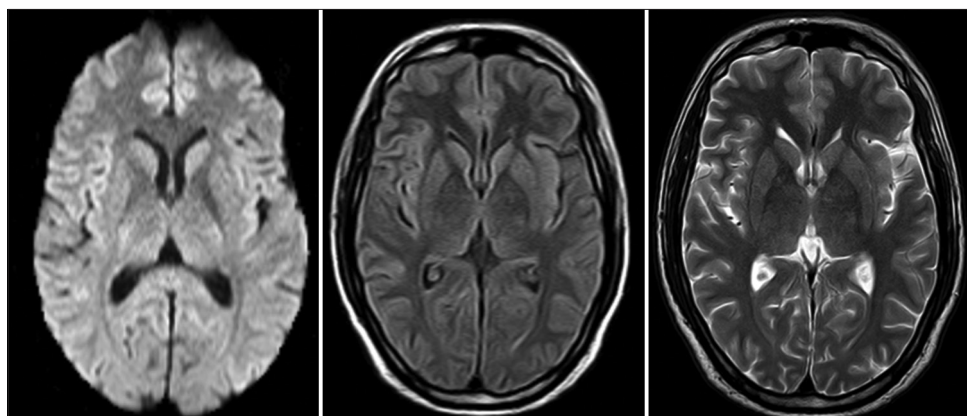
Magnetic resonance imaging brain obtained during an episode of transient neurological deficit showing no acute ischemic, inflammatory, or structural abnormality
